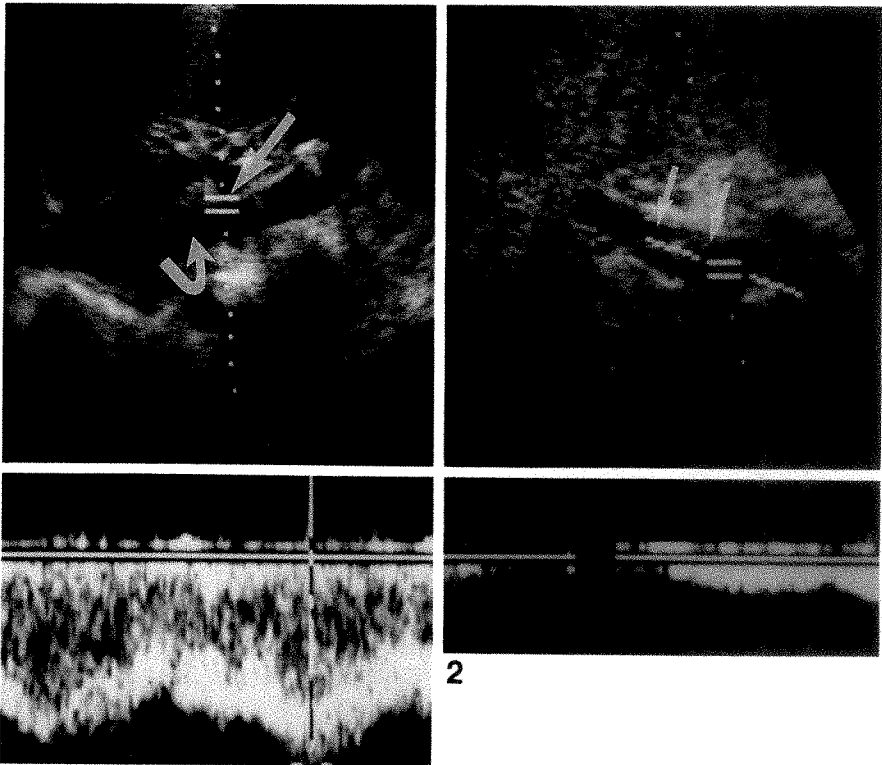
Longitudinal sonogram of partially occluded main portal vein stump shows intraluminal echoes (arrows) and low-velocity, intermittent reversed flow.
